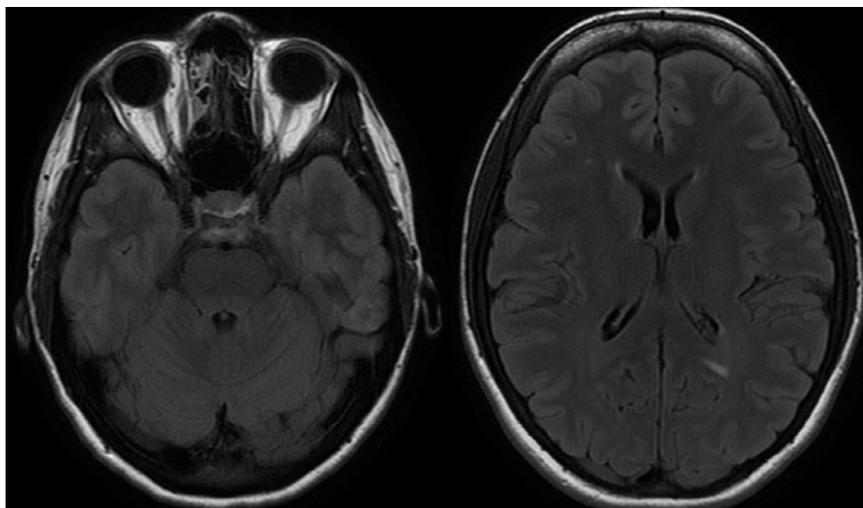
A stable, linear focus of T2 FLAIR hyperintensity is visible in the left parietal, periventricular white matter. Both optic nerves were noted as slightly smaller in size, compatible with the given clinical history of optic atrophy.
